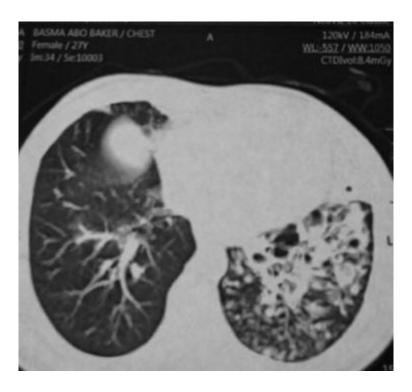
Axial view of high resolution computed tomography showing bronchiectasis at the left lower lobe with bilateral consolidations in a 27-year old female patient
